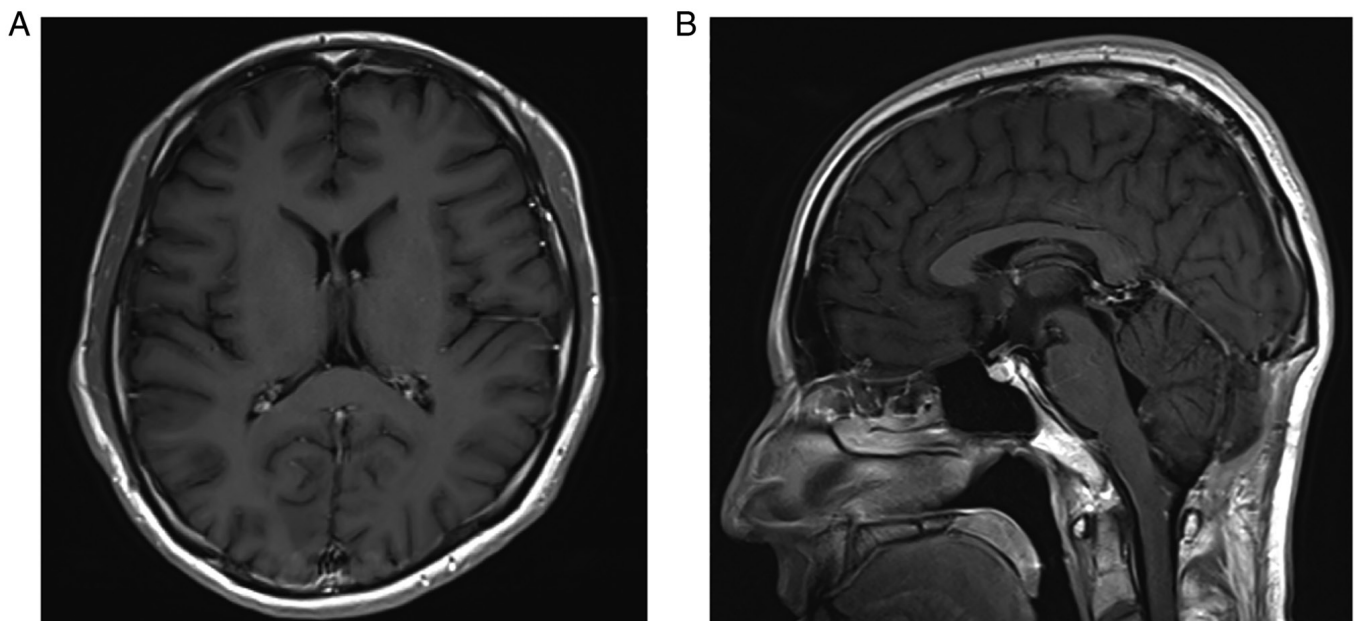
Postoperative contrast-enhanced T1-weighted images. (A) Axial view and (B) sagittal view showing the tumor in the dorsal medulla oblongata was excised and improvement of the isolated fourth ventricle.
